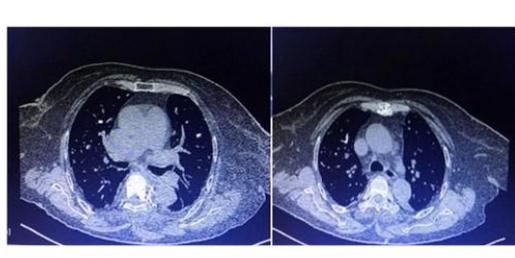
CT angiography showing filling defects in proximal and distal sub segmental pulmonary vasculature suggestive of pulmonary embolism.
